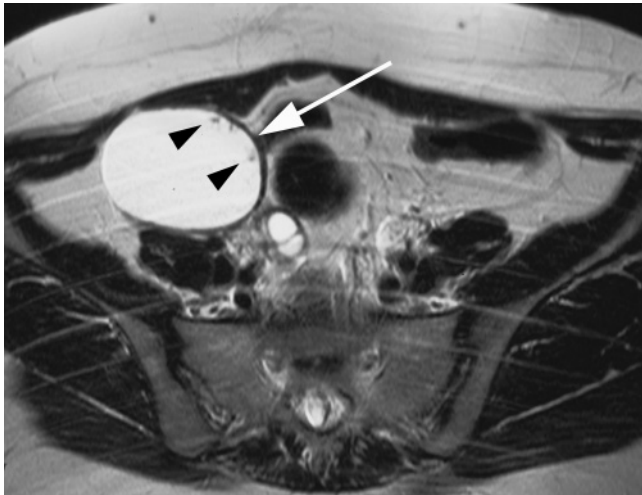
Serous cystadenoma with papillary projections. Transverse T2-weighted ETSE image shows a unilocular right adnexal mass (arrow) with a small number of papillary projects (arrowheads). Benign serous tumors may have papillary projections, but they tend to be fewer and smaller than those typically seen in malignant serous tumors.
